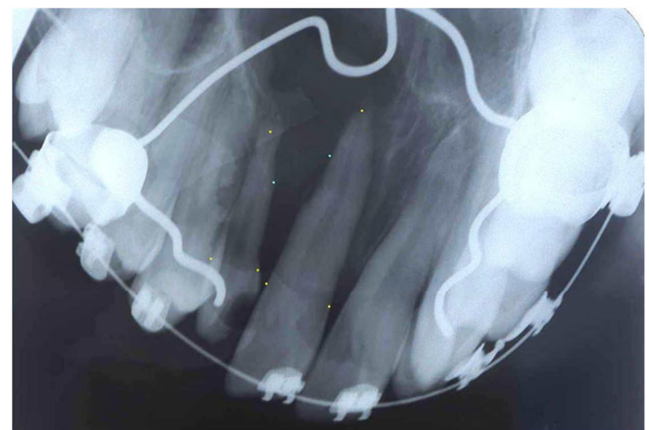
Reference points marked on Pre operative Occlusal radiographs using Microsoft Paint application. (Point 6 cannot be located as the cleft extends beyond the apex of the tooth ie $D > A$) Point 1: mesial tooth, at CEJ on mesial side. Point 2: apex of mesial tooth. Point 3: mesial tooth, at CEJ on distal side. Point 4: most coronal bone level on mesial tooth, distal aspect. Point 5: most apical level of bony bridge between mesial and distal teeth. Point 6: most coronal bone level on distal tooth, mesial aspect. Point 7: most coronal bone level on distal tooth, mesial aspect. Point 9: distal tooth, at CEJ on mesial side. Point 10: apex of distal tooth. Point 11: distal tooth, at CEJ on distal side.
